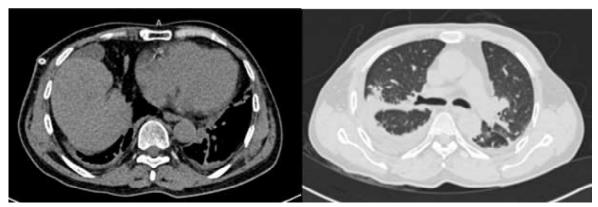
(a) Thorax CT scan (Axial section) showing herniated right lobe of liver, gall bladder, and mesenteric fat on right hemithorax. (b) Bilateral pleural effusion (more severe on the right side) with right lower lobe atelectasis due to compression
